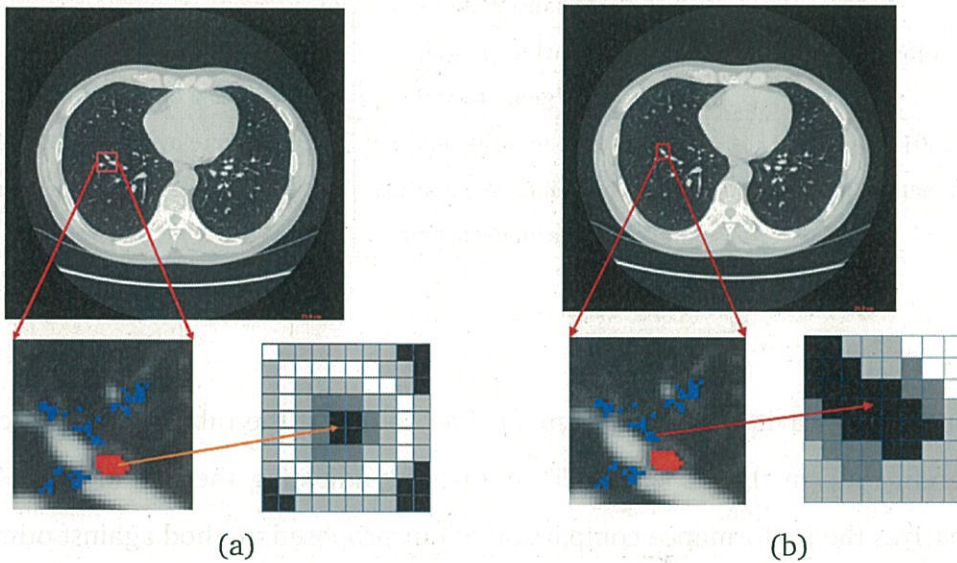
CT intensity distribution of TP region and FP region. (a) Intensity distribution of the TP region, (b) intensity distribution of FP region.
